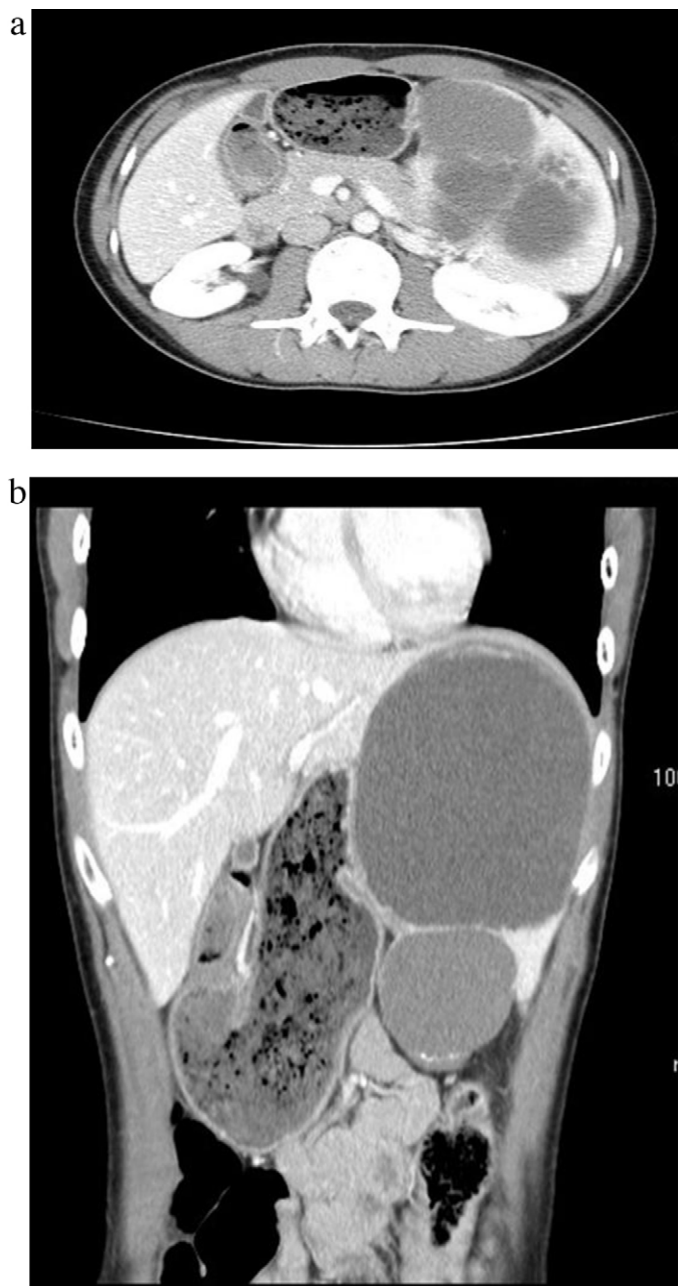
CT of abdomen shows 25-cm long splenomegaly with multilocular cystic lesion. a is horizontal image, b is coronal image.
